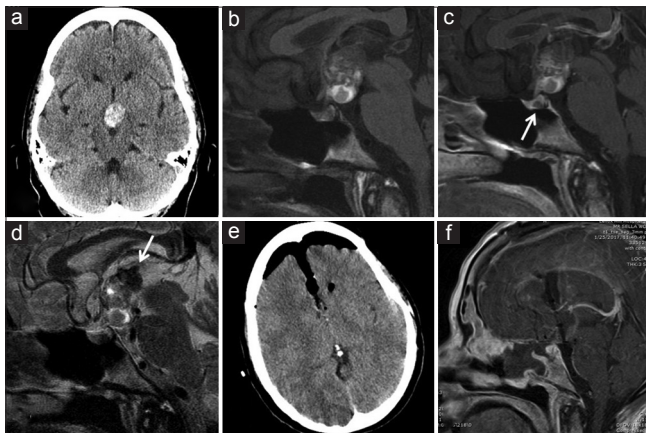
(a) Noncontrast head CT shows a heterogeneously hyperdense mass in the suprasellar cistern. (b) Sagittal T1-weighted brain MRI shows a large, partially cystic lesion without contrast, and (c) no enhancement with contrast. A small cystic lesion is seen in the pituitary gland (arrow). (d) Sagittal T2-weighted brain MRI demonstrates heterogeneous signal in the lesion. Areas of low signal superiorly (arrow) are consistent with susceptibility effects suggesting hemorrhagic products. (e, f) Postoperative noncontrast head CT (e) and brain MRI (f) demonstrate gross total resection of the lesion
